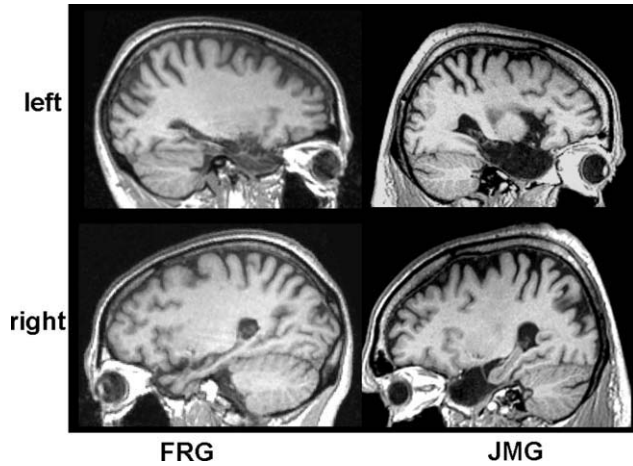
FRG and JMG lesions. Upper row: sagittal slices of the left hemisphere showing massive destruction of all MTL structures in both patients. Lower row: sagittal slices of the right hemisphere showing an opposite pattern of lesions. In FRG, right subhippocampal structures are largely preserved while the hippocampus is severely lesioned (some residual tissue can be observed within the right hippocampal area, but displaying large signal abnormalities on FLAIR sequences). In JMG, the right hippocampus was preserved while subhippocampal structures were severely lesioned, as indicated by the position of the hippocampus which plunges toward the temporal floor instead of remaining parallel to it.
